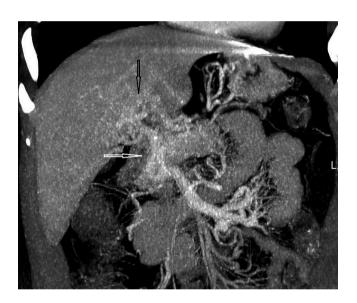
On CT angiography, there is a violation of the architectonics of the portal vein (white arrow) in the form of a set of tiny tubular formations around the portal vein (black arrow)
